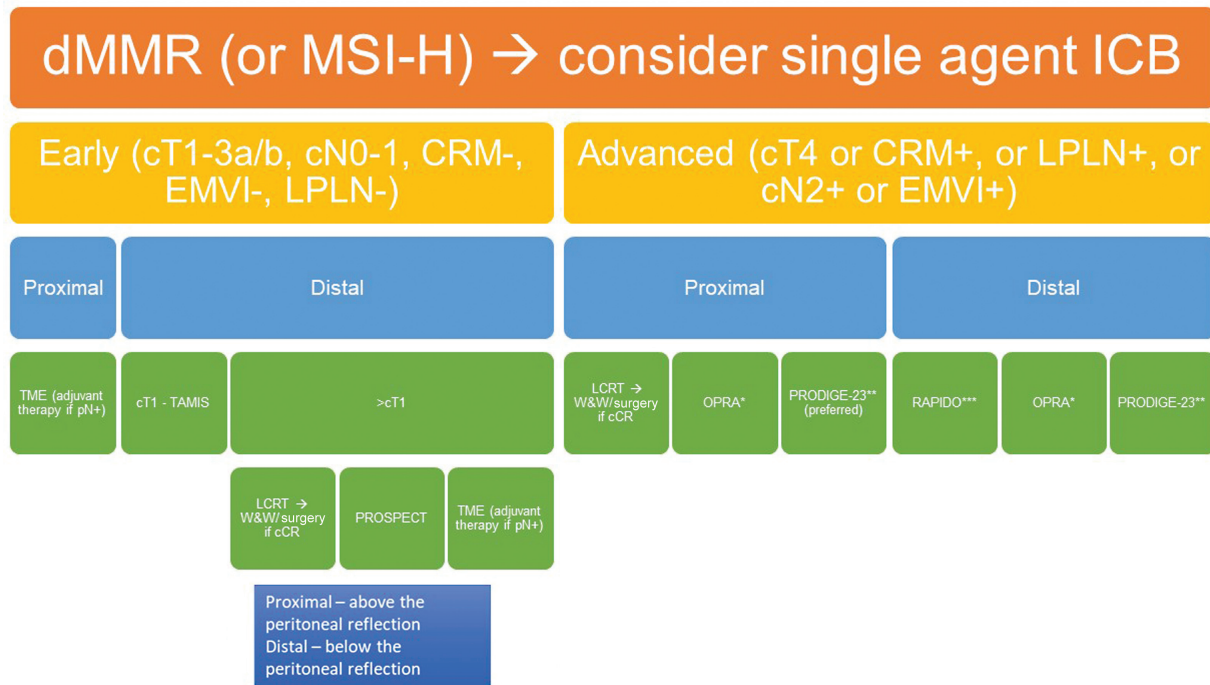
An algorithm for management of localized rectal cancer. TME – Total mesorectal excision; TAMIS – Transanal minimally invasive surgery; LCRT – 1.8 Gy x 25# radiotherapy with chemotherapy (capecitabine); PROSPECT – perspective FOLFOX and selective RT followed by TME; PRODIGE-23 – Induction mFOLFIRINOX for 2 to 3 months → LCRT → TME or W&W (if cCR); RAPIDO– SCRT→ Consolidation CAPOX or FOLFOX for 3 to 4 months → TME or W&W (if cCR); OPRA – LCRT → Consolidation CAPOX or FOLFOX for 3 to 4 months →TME or W&W (if cCR); cCR – Clinically complete response. *preferred if the goal is to achieve cCR for W&W approach; preferred if N2 or EMVI where risk of distant failure high. Adjuvant FOLFOX or COPOX after TME. *may have higher local recurrence compared to LCRT.
